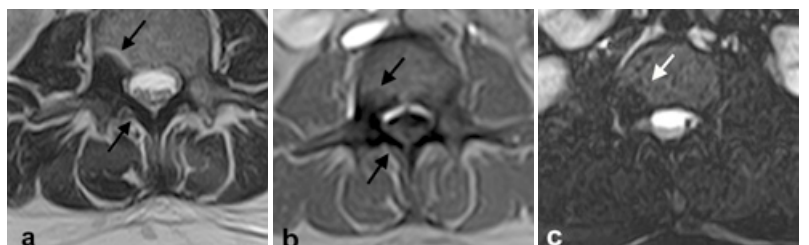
The axial MR images of the lumbar spine at the level of L2: a – T2 WI, b – T1 WI, c – T2 WI with fat saturation (FatSat) images. Focal changes in the vertebral body and vertebral arch are arrowed.
